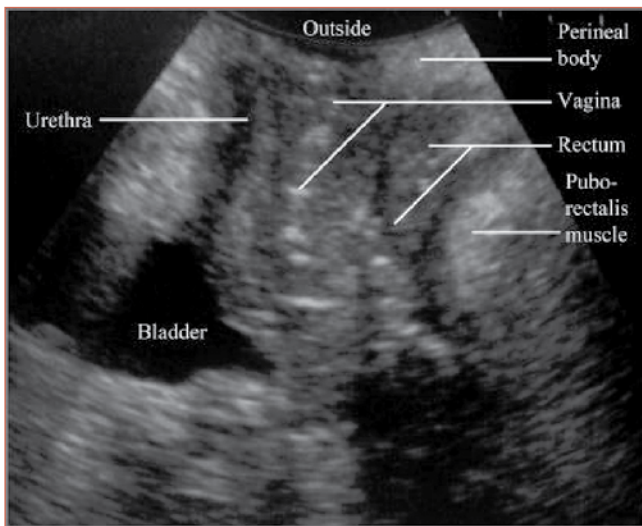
A transperineal ultrasound image of the pelvic organs
